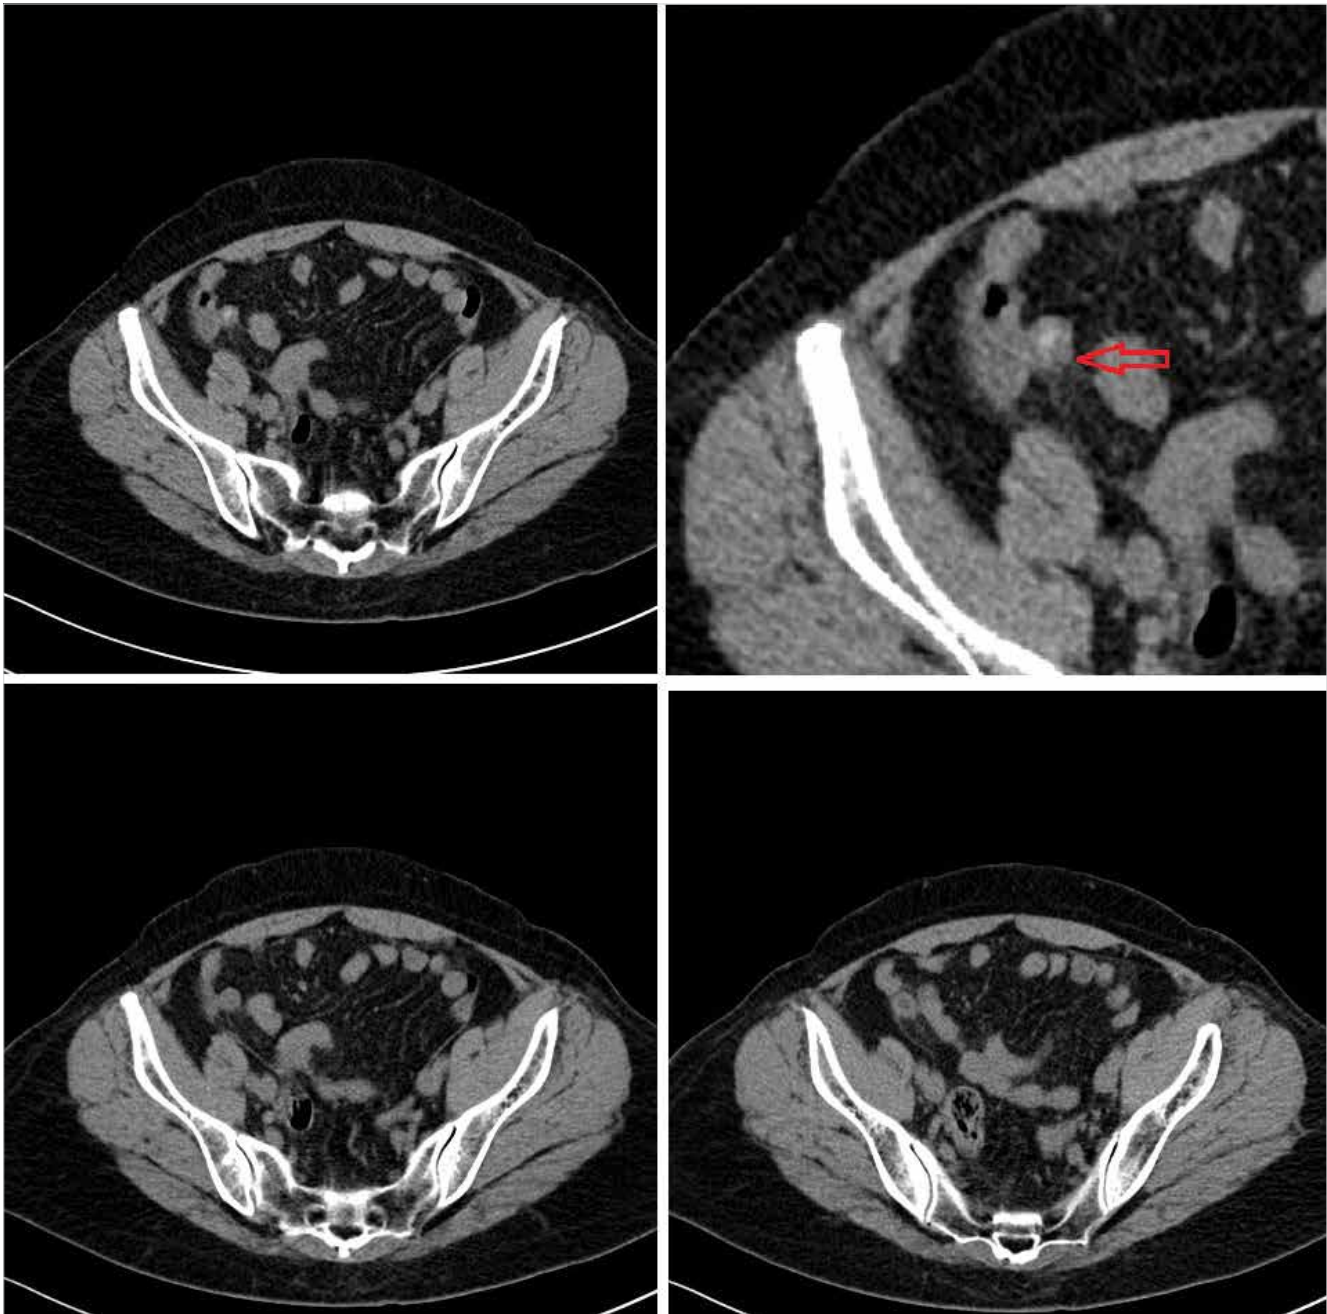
Abdominal CT images: An enlarged proximal segment of appendix (11 mm.), increased wall thickness, hyperdense material compatible with appendicolith in the lumen.
